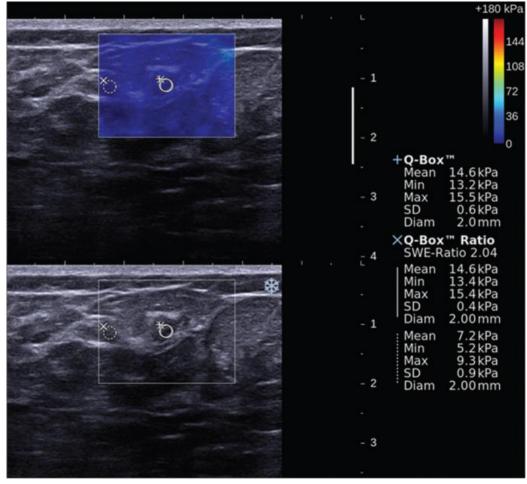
Shear wave elastographic evaluation of a BI-RADS III biopsy-proven fibroadenoma. The B-mode image is shown below the color-coded elasticity map. ROIs were delineated around the stiffest areas on the color maps. All lesions were coded blue during shear wave elastographic ultrasound examination. The ROI of breast fat tissue was of the same size and depth as that of the corresponding lesion. Mean lesion elasticity, 14.6 kPa; mean fat tissue elasticity, 7.2 kPa; mass/fat ratio, 2.04; ROI diameter, 2 mm (38)
